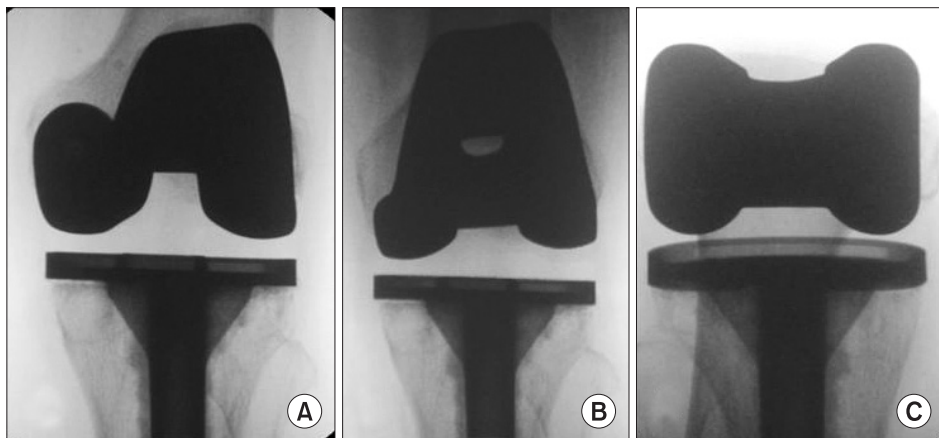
Anteroposterior radiographs by an X-ray image intensifier showing tibio-femoral medial-lateral gap ratio changes according to different flexion angles at postoperative 6 months. (A) 0° flexion. (B) 90° flexion. (C) 130° flexion.
